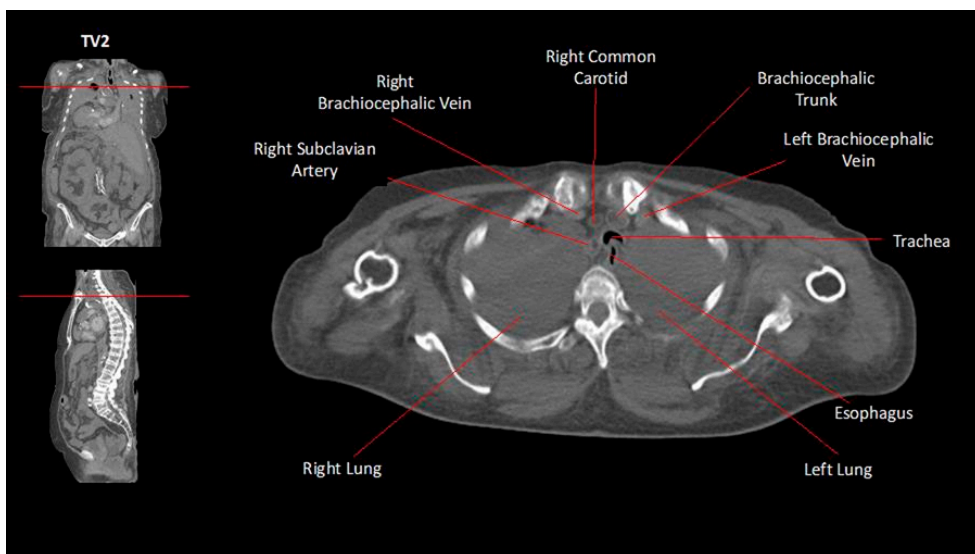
CT imaging of the great vessels of the superior mediastinum at the thoracic vertebral level 2 (TV 2). The right common carotid artery and right subclavian artery are identified as direct branches from the arch of the aorta and the brachiocephalic trunk is identified on the left. The red lines in the coronal and sagittal images denote the vertebral level.
